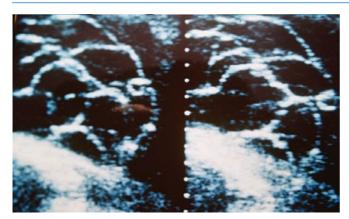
Multiseptate on ultrasound
